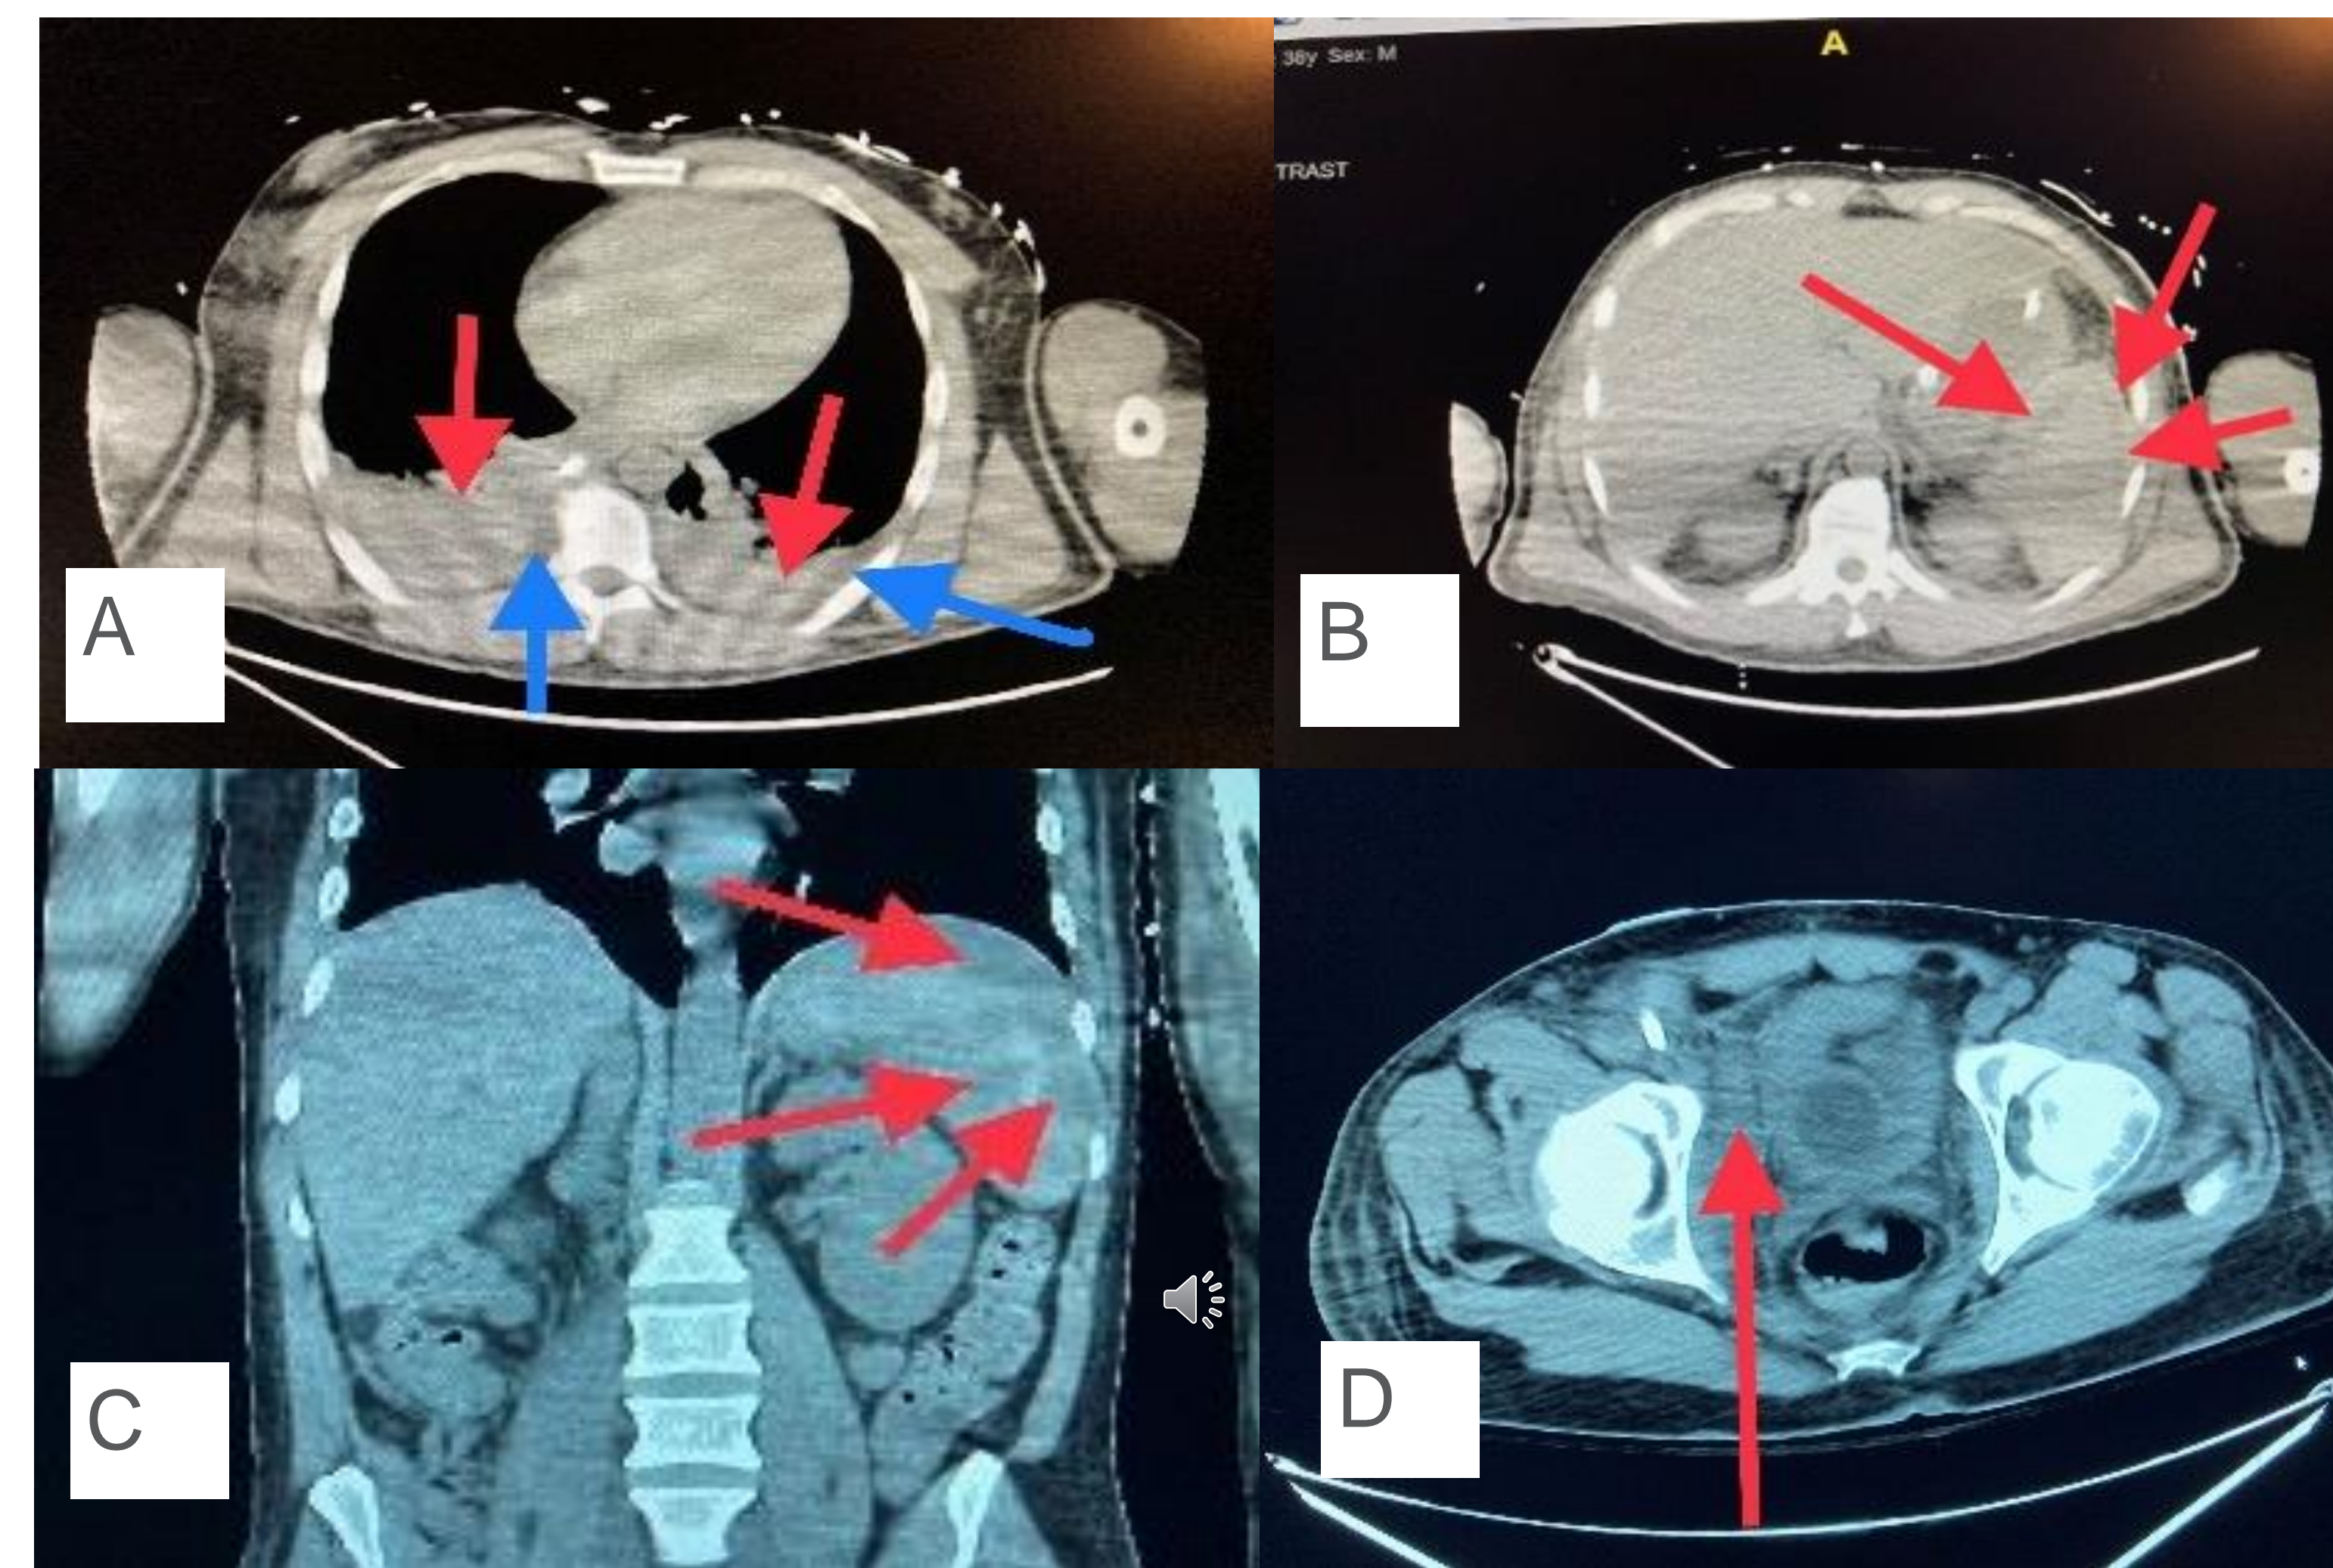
Computerized tomography (CT) chest, abdomen, and pelvis. A) The red lines are pointing toward bilateral pleural effusions. The blue lines are pointing towards hypointense densities, which indicate bilateral atelectasis. B) A subcapsular hematoma is present on the anterolateral aspects of the spleen. C) The hypointense lesions show multiple splenic infarcts. D) Right extraperitoneal hematoma.
